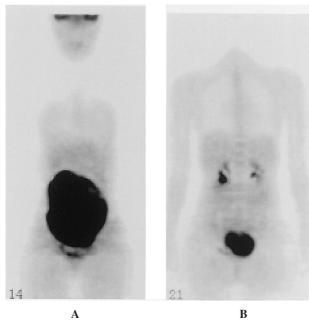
¹⁸F-FDG PET before operation and chemotherapy revealed strong uptake in abdominal masses. (A) The mass of the right ovary showed strong uptake. (B) The mass of the left ovary showed strong uptake.
